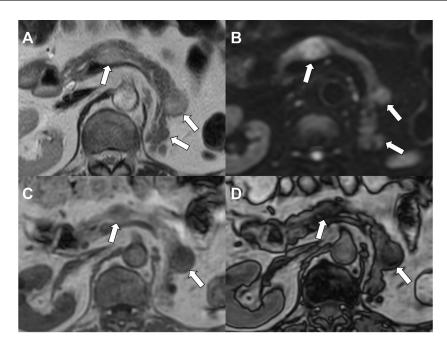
Magnetic resonance imaging (MRI). (A) T2-weighted image (T2WI), (B) Diffusion-weighted image (DWI), (C) In-phase of T1-weighted image (T1WI), (D) Opposed-phase of T1WI. Pancreatic tumors show mild high signal intensity on T2WI and high signal intensity on DWI. They exhibit reduced signal intensity from in-phase to opposed-phase T1WI, indicating the presence of fat (arrows).
